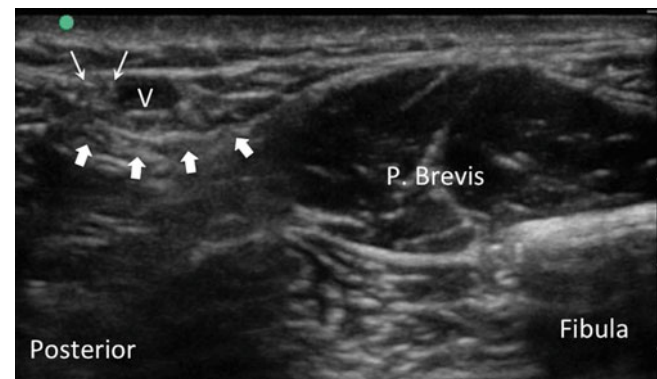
Sonography of the sural nerve (indicated by *line arrows*). It is accompanied by the lesser saphenous vein and both are located within the fascia plane (*block arrows*) posterior to the peroneus brevis muscle (Reproduced with permission from Philip Peng Educational Series)
